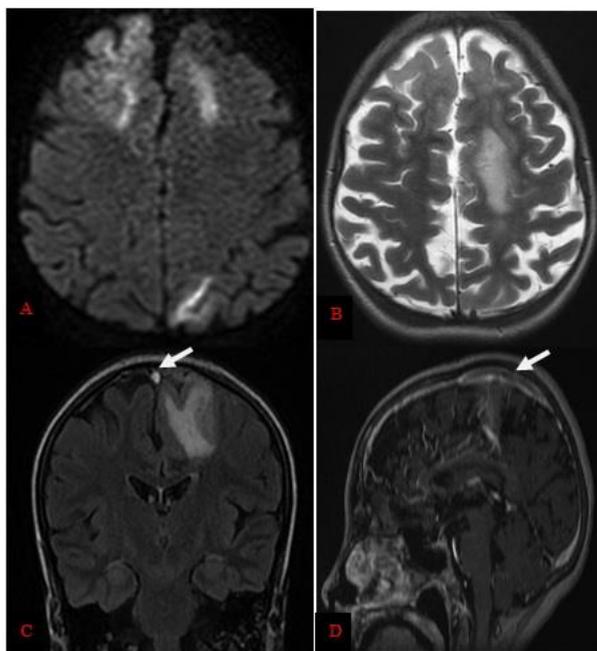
Axial diffusion (A), axial T2-weighted (B) and coronal FLAIR (C) MR images show bilateral frontal venous infarcts with hypertensity of the longitudinal sinus on coronal FLAIR image (C). Sagittal T1-weighted MR image with contrast-enhanced (D) shows thrombosis of superior sagittal sinus
